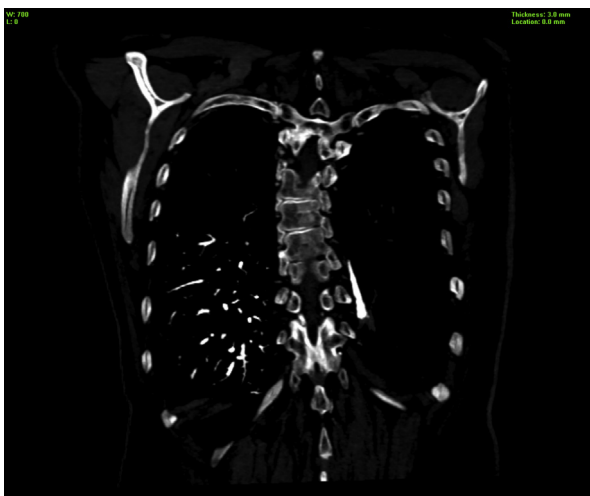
Coronal slice of contrast-enhanced computed tomographic scan showing micro-arteriovenous malformations in the right lung. Homogenous, well-circumscribed nodules can be seen in the right middle and right lower lobes. There is enhancement of the feeding artery, the aneurysmal part, and the draining vein. No macro-arteriovenous malformations are visualized.
